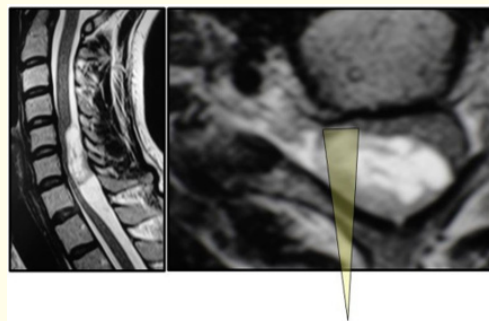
Sagittal (left) and axial (right) T2 weighted MR images of the posterior cervical lesion are seen. The posterolateral triangle represents the possible safe trajectory for surgical exposure of the tumor.
